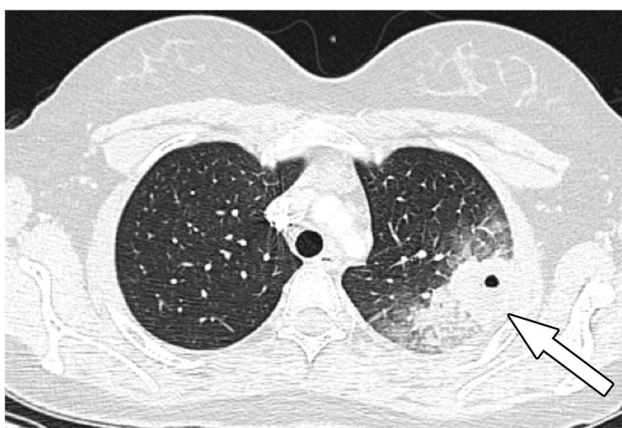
16-year-old girl with acute fungal infection due to coccidioidomycosis. Axial chest CT image with IV contrast material shows left upper lobe consolidation (arrow) with central cavitation and surrounding ground glass opacity
